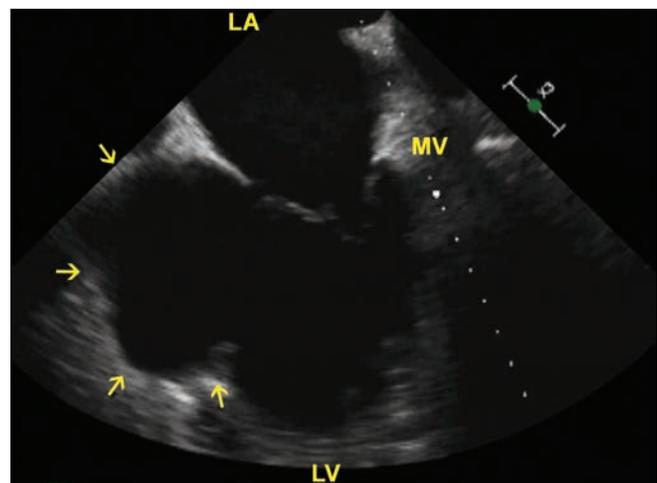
Transesophageal echocardiography. Shows same findings as above.
